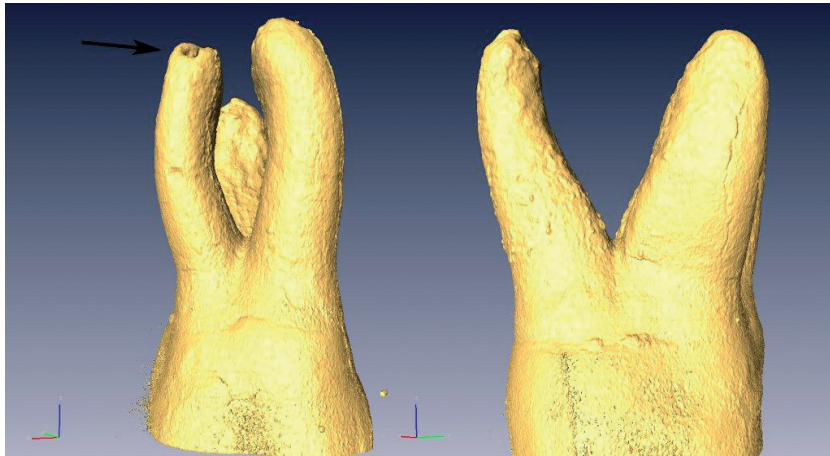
Bucco-lingual (left) and mesio-distal (right) views of a first upper molar with three roots. It is possible to appreciate (arrow) the apical resorption of the bucco-distal root, probably due to periapical pathology.
